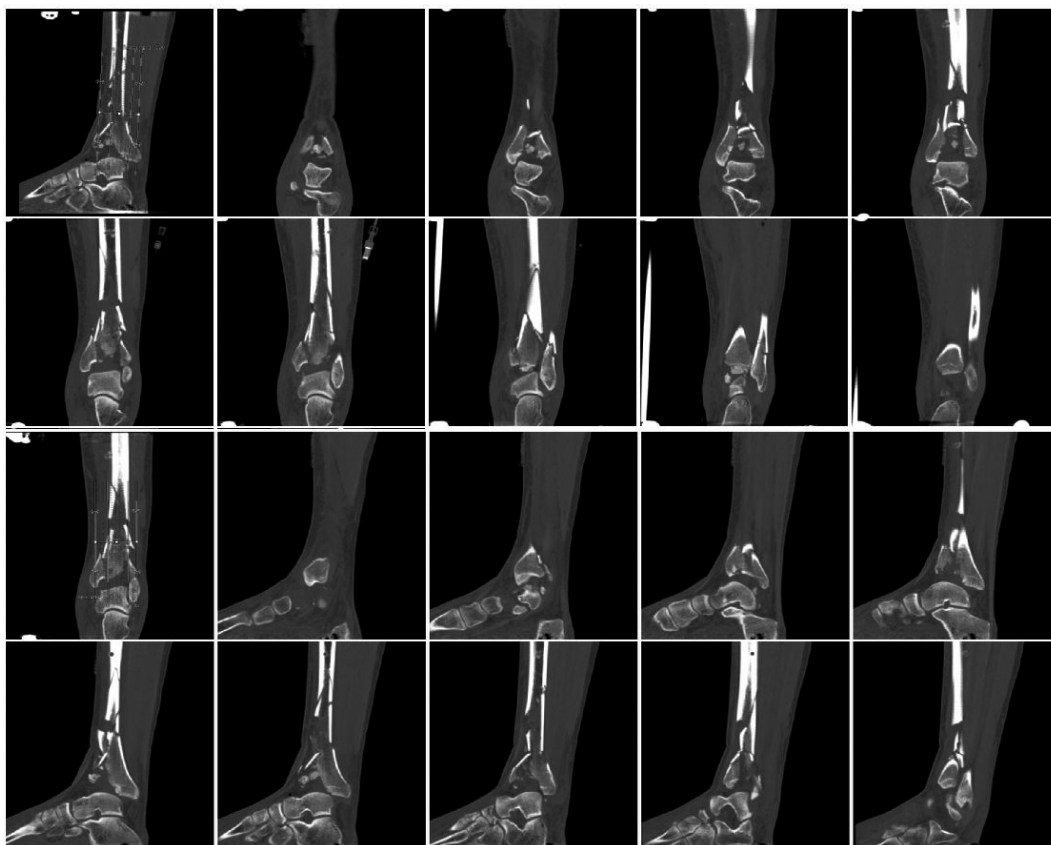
Coronal and sagittal reconstructions of the CT scan of the fracture that was presented in Figure 1.
